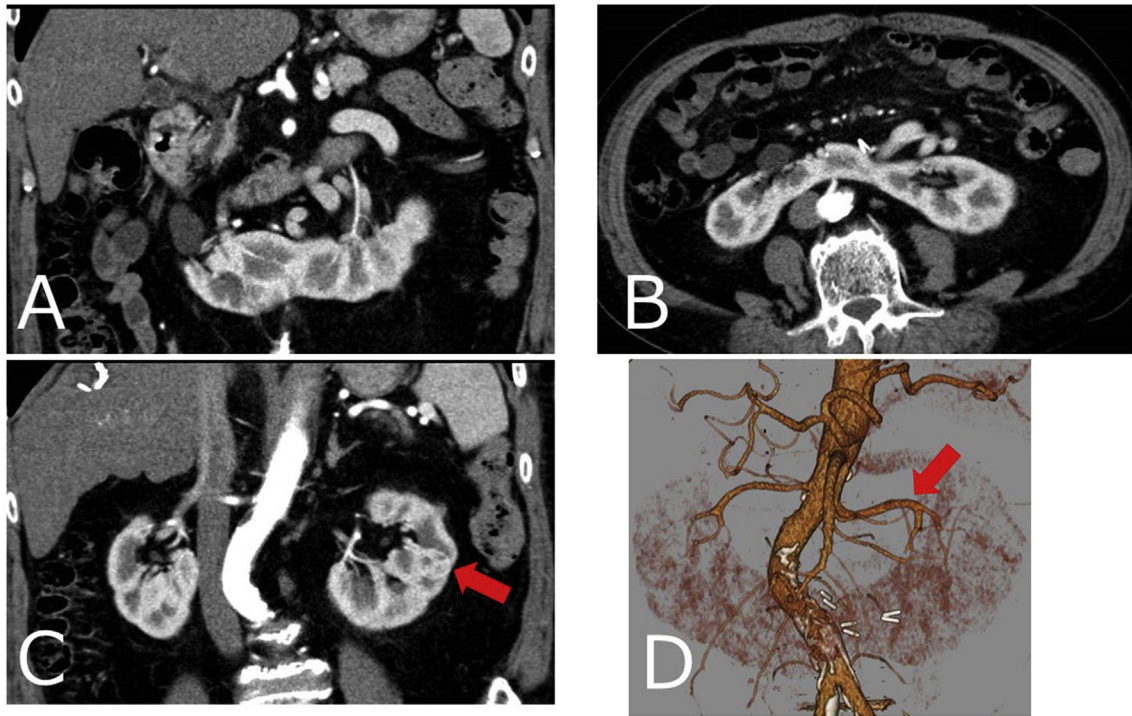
Abdominal enhanced CT showing renal tumor with horseshoe kidney. (A) Coronal image revealing the isthmus. (B) Axial image revealing the isthmus. (C) Coronal image: left renal cell carcinoma of 1.6 cm (arrow) in diameter in the arterial phase. (D) Three-dimensional CT arterial image: the shape of horseshoe kidney and only one artery nourishing the left kidney (arrow).
